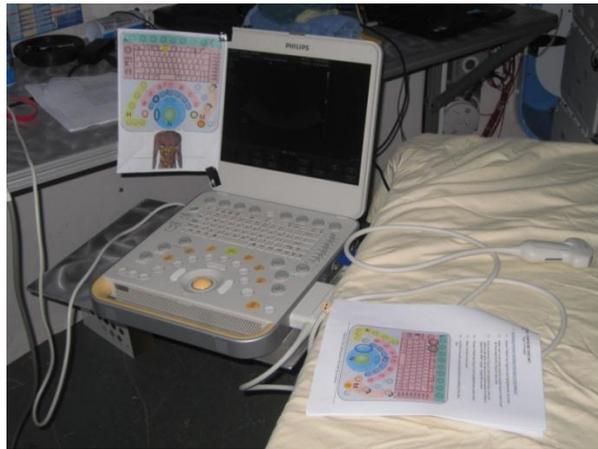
Deployment of the MOWS examination table and utility shelf. The CX-50 ultrasound device can be seen on the utility shelf.
